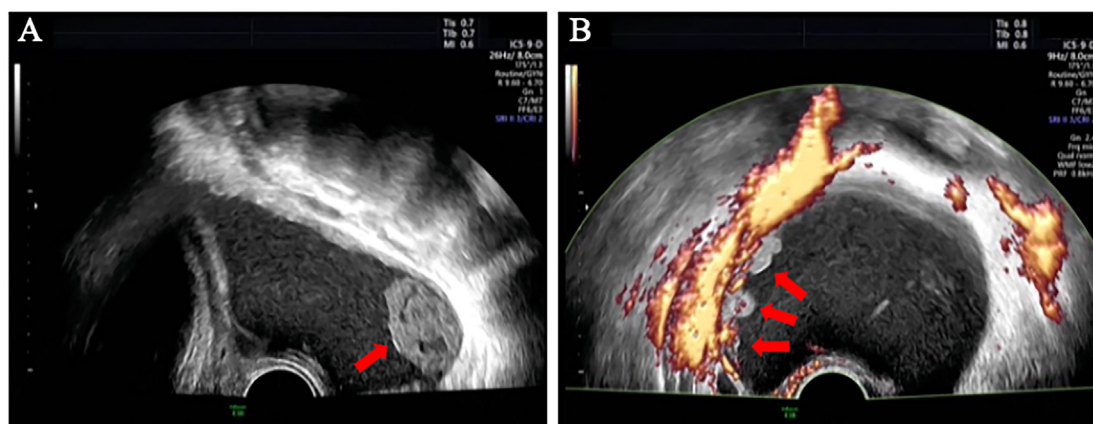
Left ovarian cyst of case 1 at 37⁺⁵ weeks of gestation under ultrasound.
